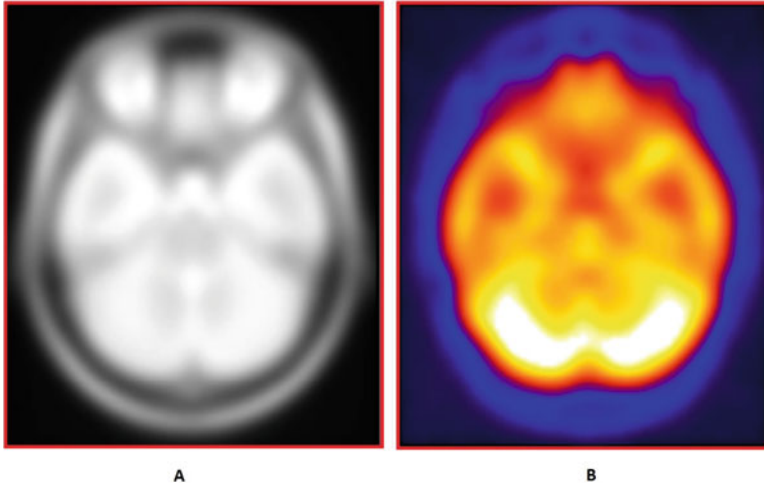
Initial slices. (a) PD-MRI, (b) PET
